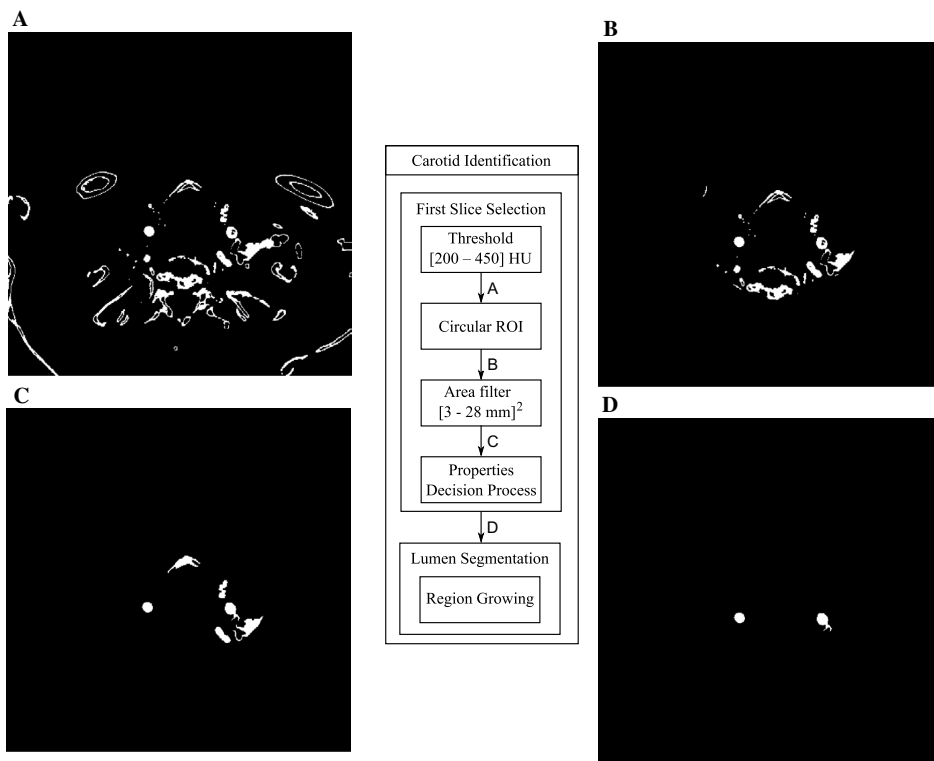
Carotid identification scheme in CTA (example intermediate results A, B, C and D)
